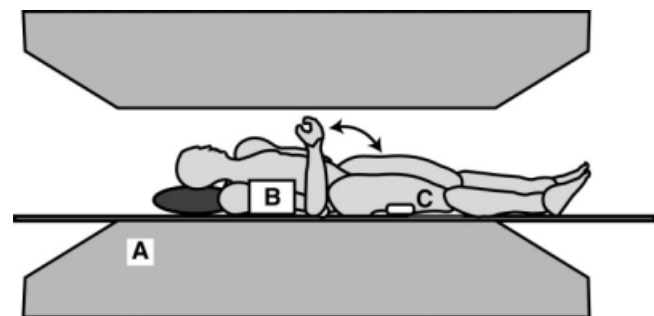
Experimental setup. The subjects were positioned on their side on the table of a 1.5-T GE Signa CV/i MR scanner (A) with a flexible radio-frequency surface coil around their dominant arm (B). This positioning and radio-frequency coil were used for both the real-time PC and cine PC image data acquisition. The subjects flexed and extended the elbow through at least a 45° range of motion at a rate of 35 cycles/minute against the load of gravity. For cine PC MRI, an optical transducer (C) was used to signal the beginning of each motion cycle.
